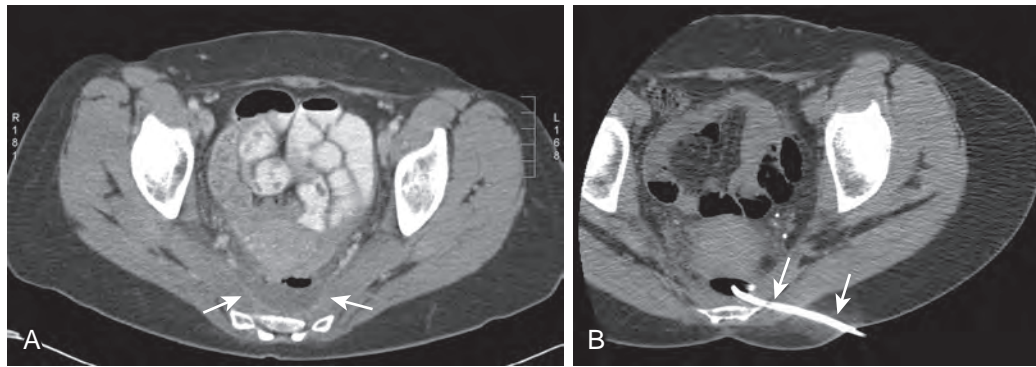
Transgluteal drainage of presacral abscess. A. Contrast-enhanced axial CT image shows a presacral abscess with an air-fluid level (arrows) in a 67-year-old patient with rectal cancer after rectal cancer surgery. B. CT-guided transgluteal drainage of the abscess was performed with placement of the catheter into the presacral abscess (arrows).
